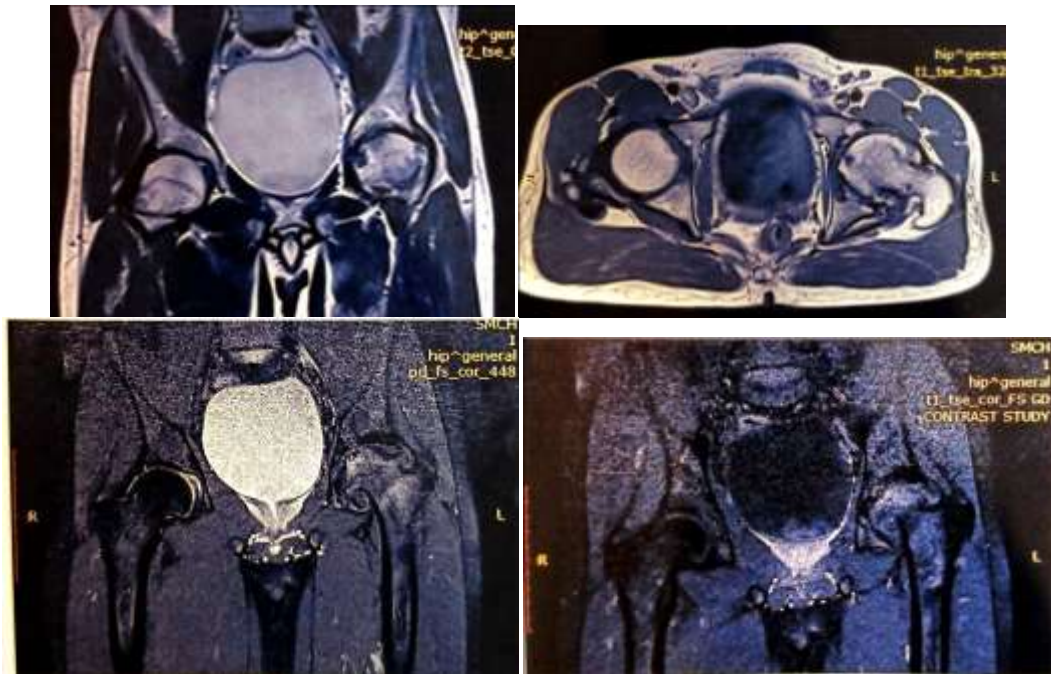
Avascular necrosis of hip: Plain radiograph shows subchondral sclerosis with subchondral collapse of femoral head, joint space narrowing and lateral acetabular marginal osteophytes. CT shows contour irregularity, subchondral sclerosis and mild flattening of femoral head, joint space narrowing & lateral marginal osteophytes. MRI shows flattening of femoral head with irregular contour. Areas of T1& T2 hypointensities showing no post contrast enhancements, suggesting sclerosis, marrow edema showing post contrast enhancement with joint space reduction and marginal osteophytes.
